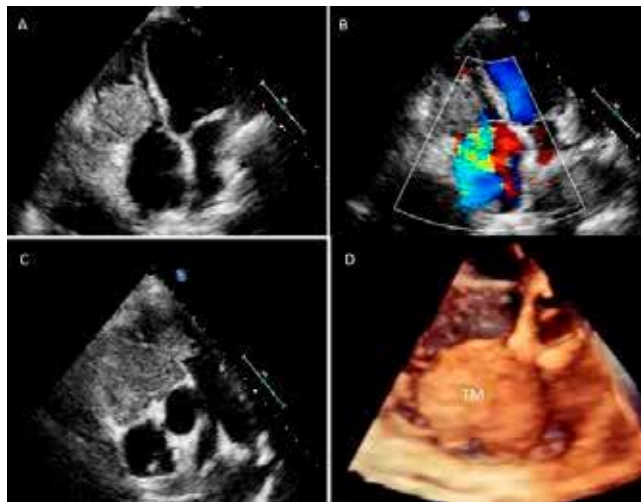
The giant, irregular polypoid shaped, heterogeneous, semi-mobile right VENTRICULAR mass in transthoracic echocardiography Figure 1B: The mass filling the right VENTRICLE causing a coaptation defect of the tricuspid cusps resulting SEVERE tricuspid regurgitation and the right atrial mass in transthoracic echocardiography Figure 1C: Right VENTRICULAR mass extending into the right VENTRICLE outflow tract and main pulmonary artery, right atrial mass in transthoracic echocardiography. Figure 1D: 3D echocardiographic VIEW of the right VENTRICULAR mass extending into right VENTRICULAR outflow tract
